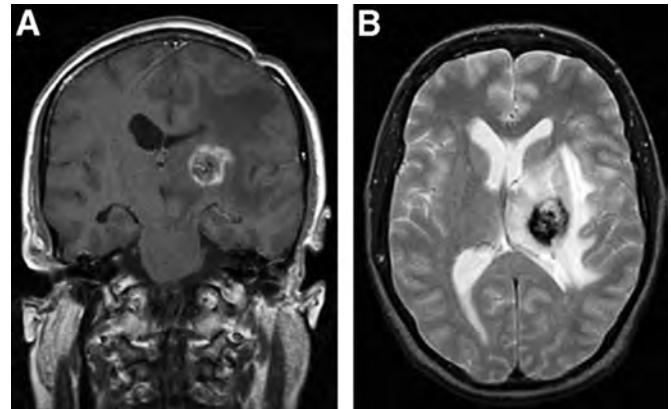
MRI was performed 11 months after radiosurgery of a left thalamic cavernous malformation (margin dose, 18 Gy; maximum dose, 30 Gy; volume 1.0 cc). *A*, Coronal postgadolinium study showing area of enhancement larger than the irradiated volume. *B*, Axial T2-weighted MRI showing extensive edema and mass effect.
